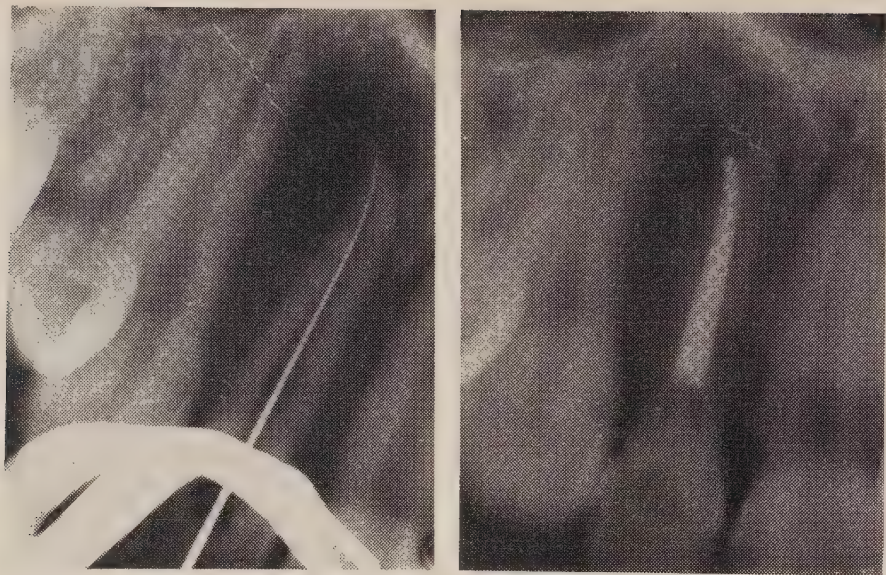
Radiographs of periapical lesion (l. November 16, 1962; r. September 3, 1963) which healed following non-surgical endodontic treatment.
